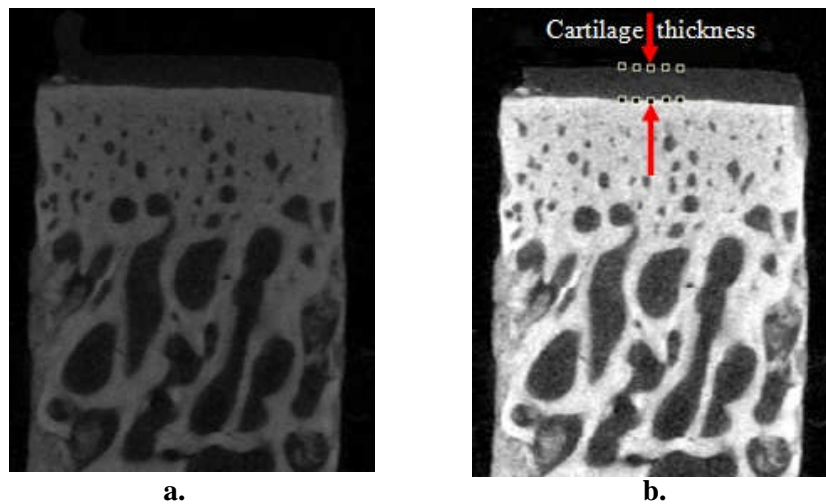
a. Image from μ CT scan, b. Cartilage thickness measurement after image processing.
